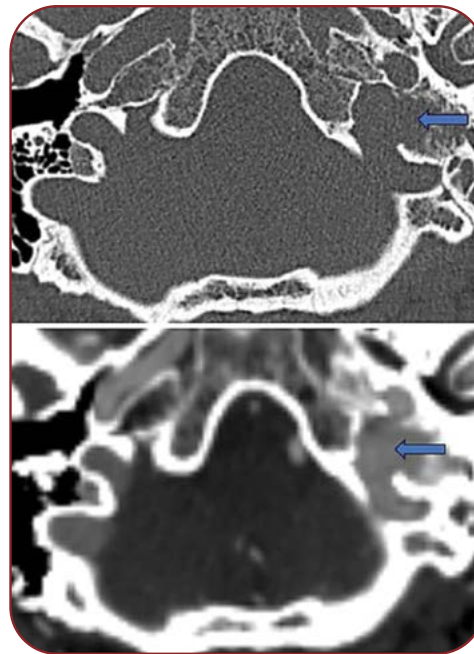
Case 2: jugulotympanic paraganglioma. On high resolution computed tomography (HRCT) temporal bone axial images, a relatively well-defined lytic lesion (closed arrow) is seen in the left jugular fossa involving the pars nervosa and pars vascularis, causing widening of the jugular fossa with associated scalloping and erosion of the jugular spine. The lesion is eroding the posterior wall of the carotid canal. On computed tomography (CT) angiography, the lesion shows avid enhancement.
